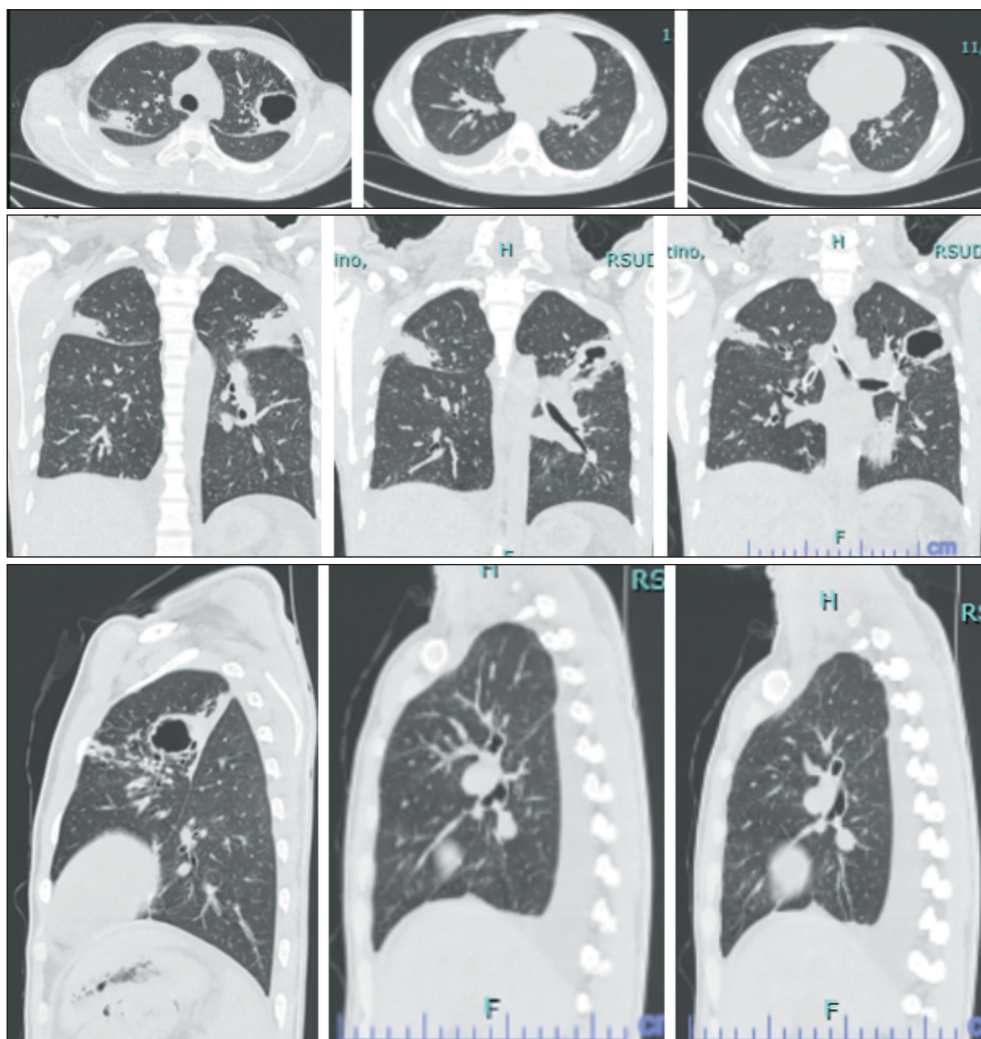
HRCT shows pulmonary tuberculosis with right pleural effusion, bilateral upper paratracheal lymphadenopathy, and left peribronchial lymphadenopathy.
